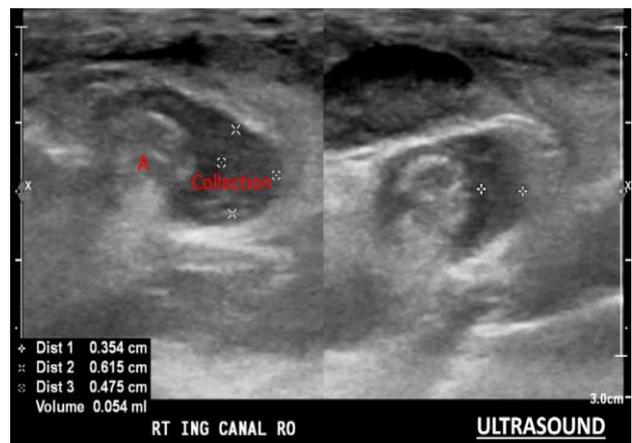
Axial ultrasound demonstrating the appendix with an adjacent collection measuring 6.2×4.8×3.5 mm.
